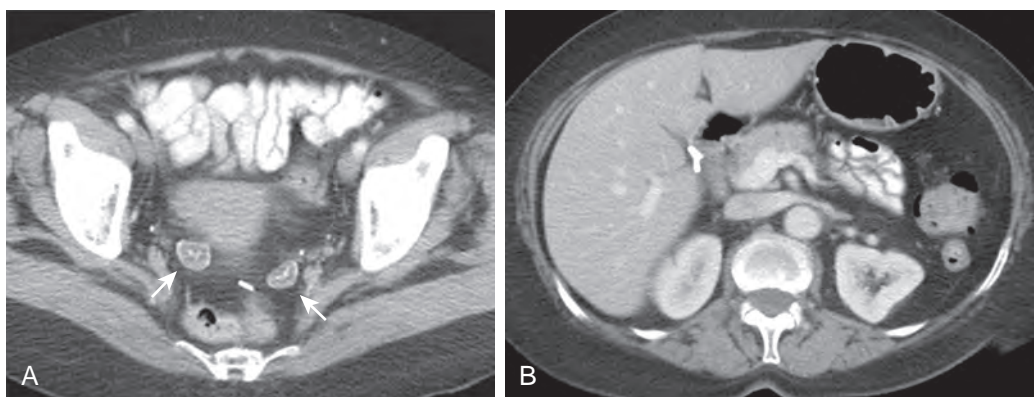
Spilled gallstones after laparoscopic cholecystectomy with stones located in the pelvis. A. Contrast-enhanced CT demonstrates two partially calcified stones in the pelvis (arrows). A surgical clip is also noted. B. Clips are present in the otherwise empty gallbladder fossa, compatible with prior cholecystectomy.
